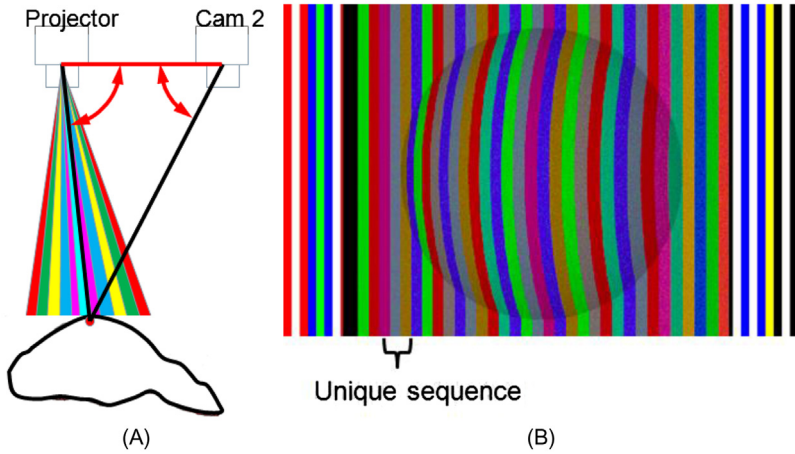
(A) and (B) The “structured light” approach requires one (calibrated) light projector and a camera to obtain 3D data. *Courtesy: Dr. P. Rentschler, SIEMENS CT, Munich, Germany.*
